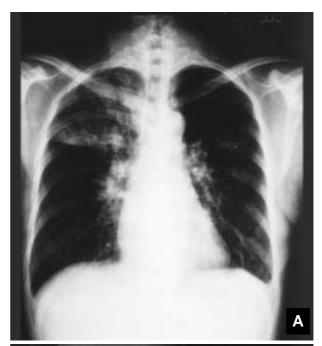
The chest roentgenography, PA view (A) and lateral view (B), revealed normal heart size, patchy densities at right upper and left middle lung field, linear atelectasis noted at left basal lung and blunted left C-P angle.
